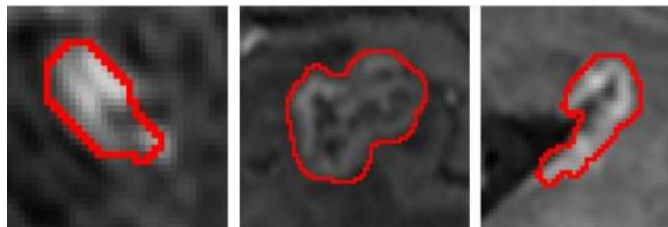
MRI Brain Tumor image Structure Examples
